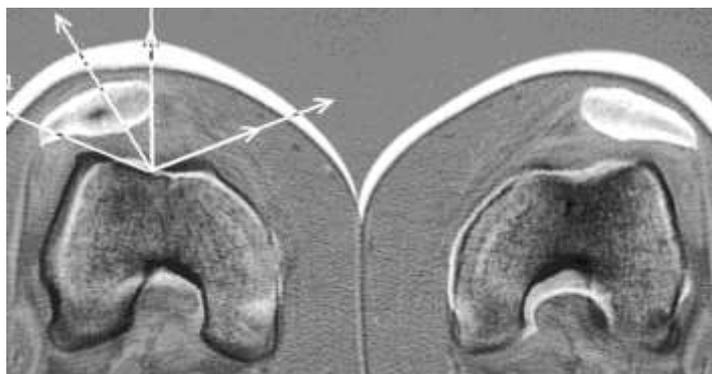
CT at 0° from a patient with anterior knee pain in the right knee, however the left knee is completely asymptomatic. In both knees the PFM is symmetric. (Reprinted from [61]. With kind permission of Springer Science + Business)
